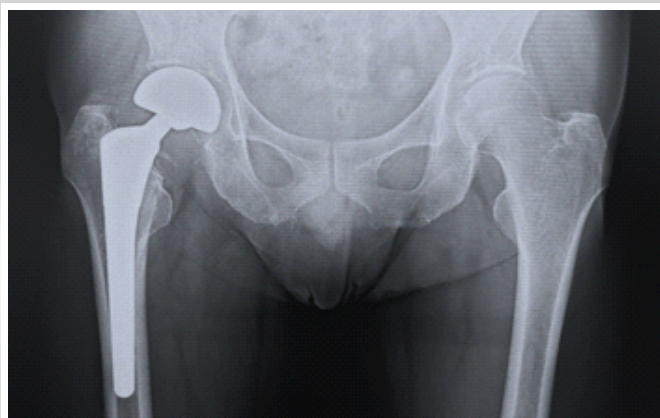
Radiograph in year X-8. Bipolar hemiarthroplasty has been performed.
